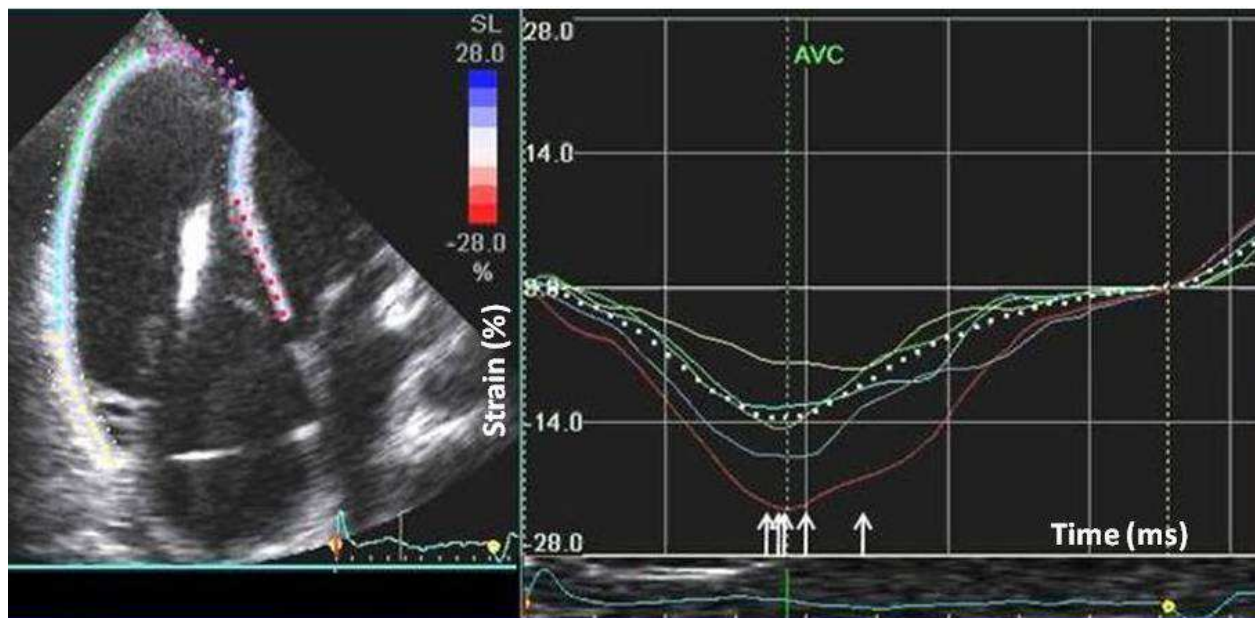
Strain curves in an patient with arrhythmogenic right ventricular cardiomyopathy. Strain curves from a dilated right ventricle from apical 4 chamber view. Vertical arrows indicate the timing of maximum myocardial shortening in each right ventricular segment and are consistent with pronounced right ventricular mechanical dispersion.
